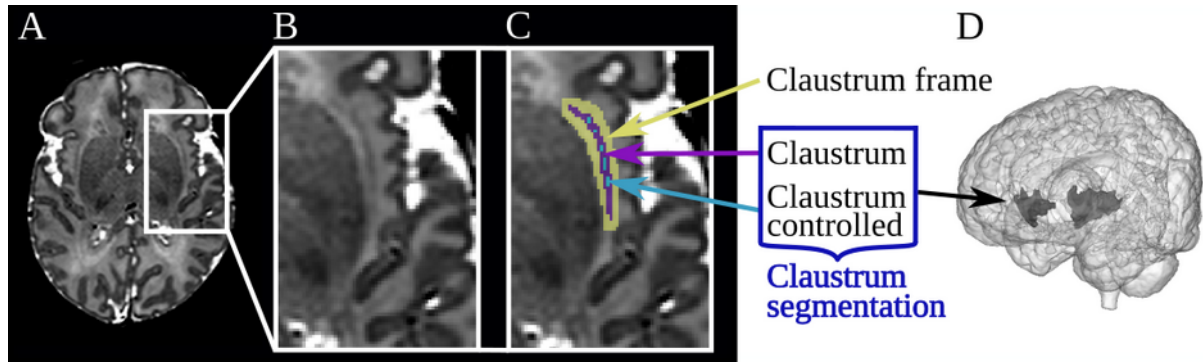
Clastrum segmentation in neonatal brain MRI.
